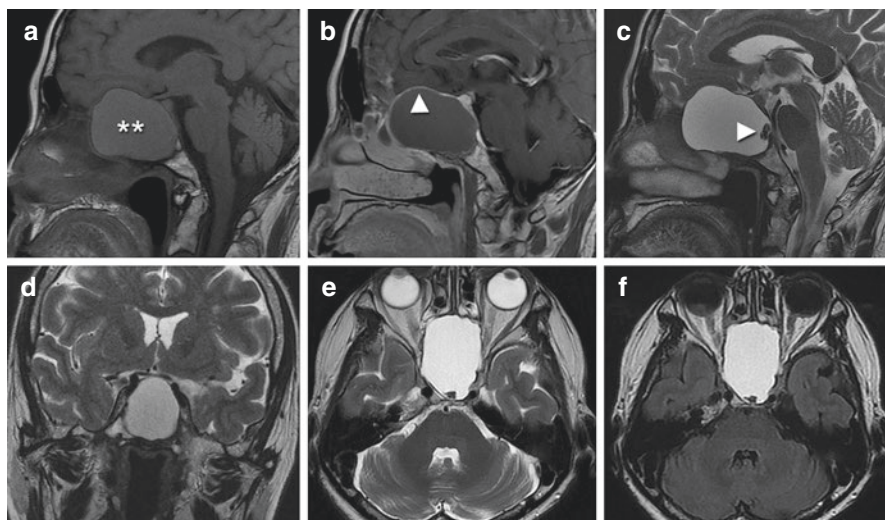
Isolated giant fungal mucocele of the sphenoid sinus. Preoperative MR images (a–f)
